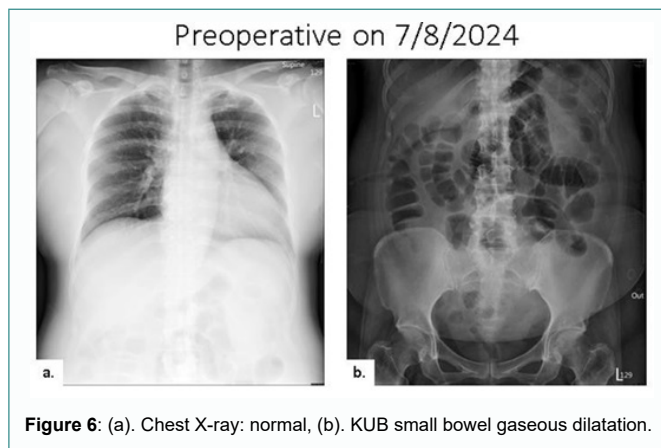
(a). Chest X-ray: normal, (b). KUB small bowel gaseous dilatation.
